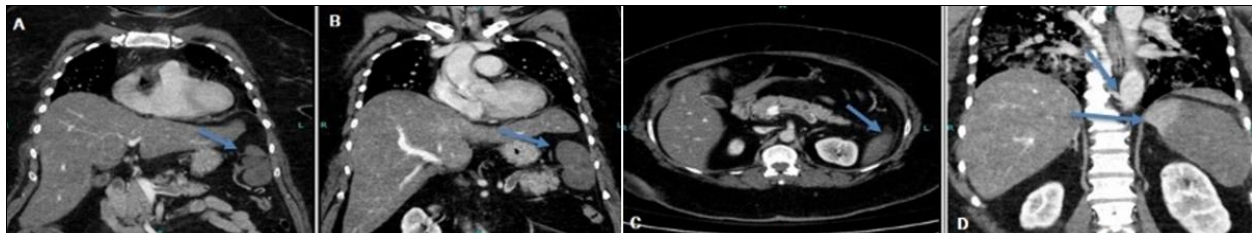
CT scan of the abdomen showing filling defect in the splenic veins (A, B) which is causing splenic infarcts (C, D)
